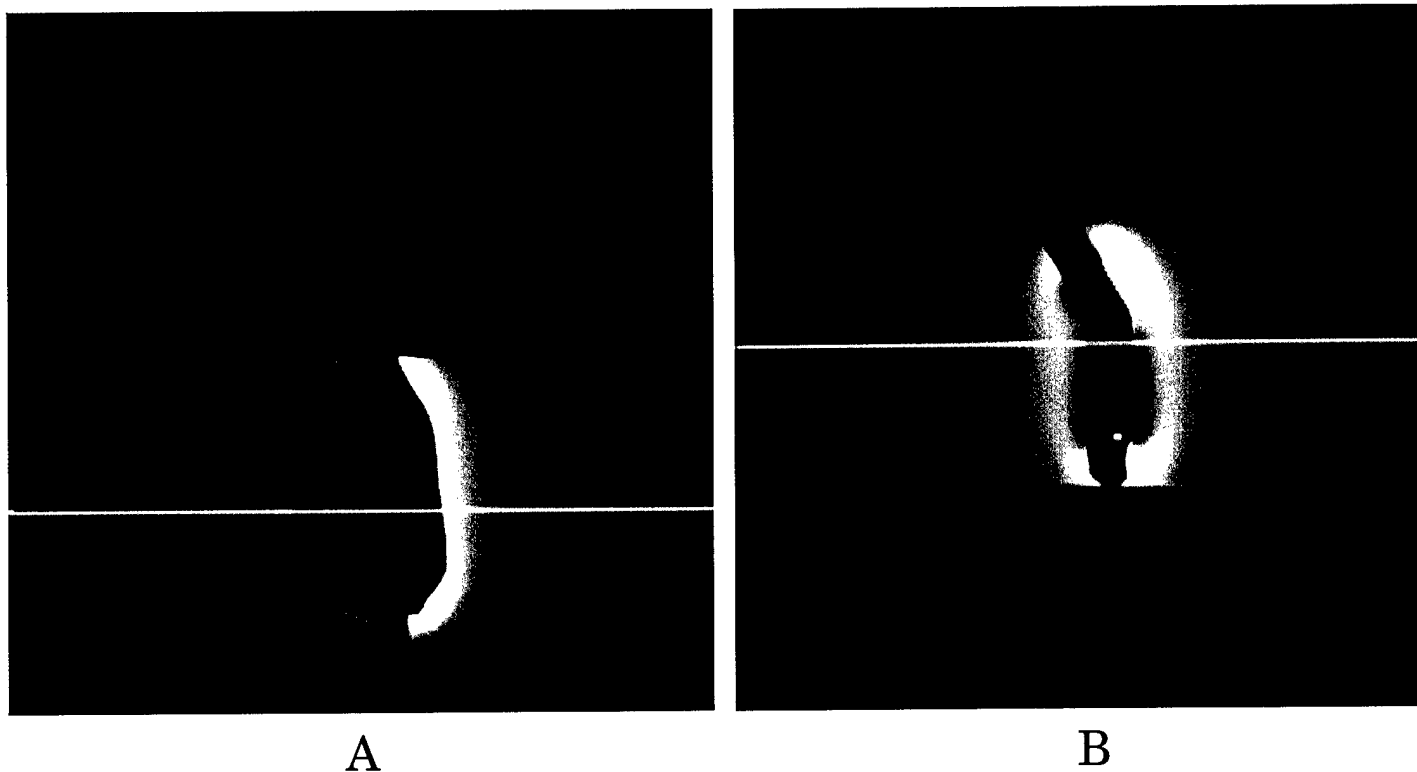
MR images acquired with A) a Med-Rad prostate probe and B) the GE-built probe. The horizontal line through each image indicates the region of the image analyzed in Figure 5.
